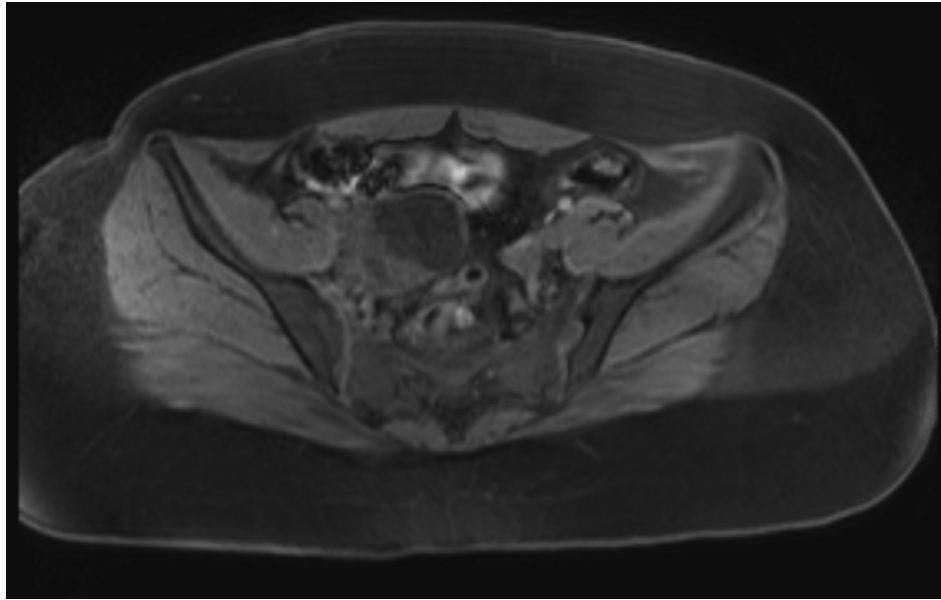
Representative image of teratoma on MRI; transverse T1 series with contrast.
